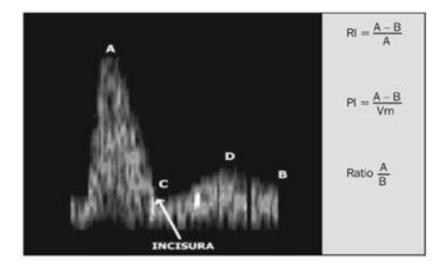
Doppler indices
